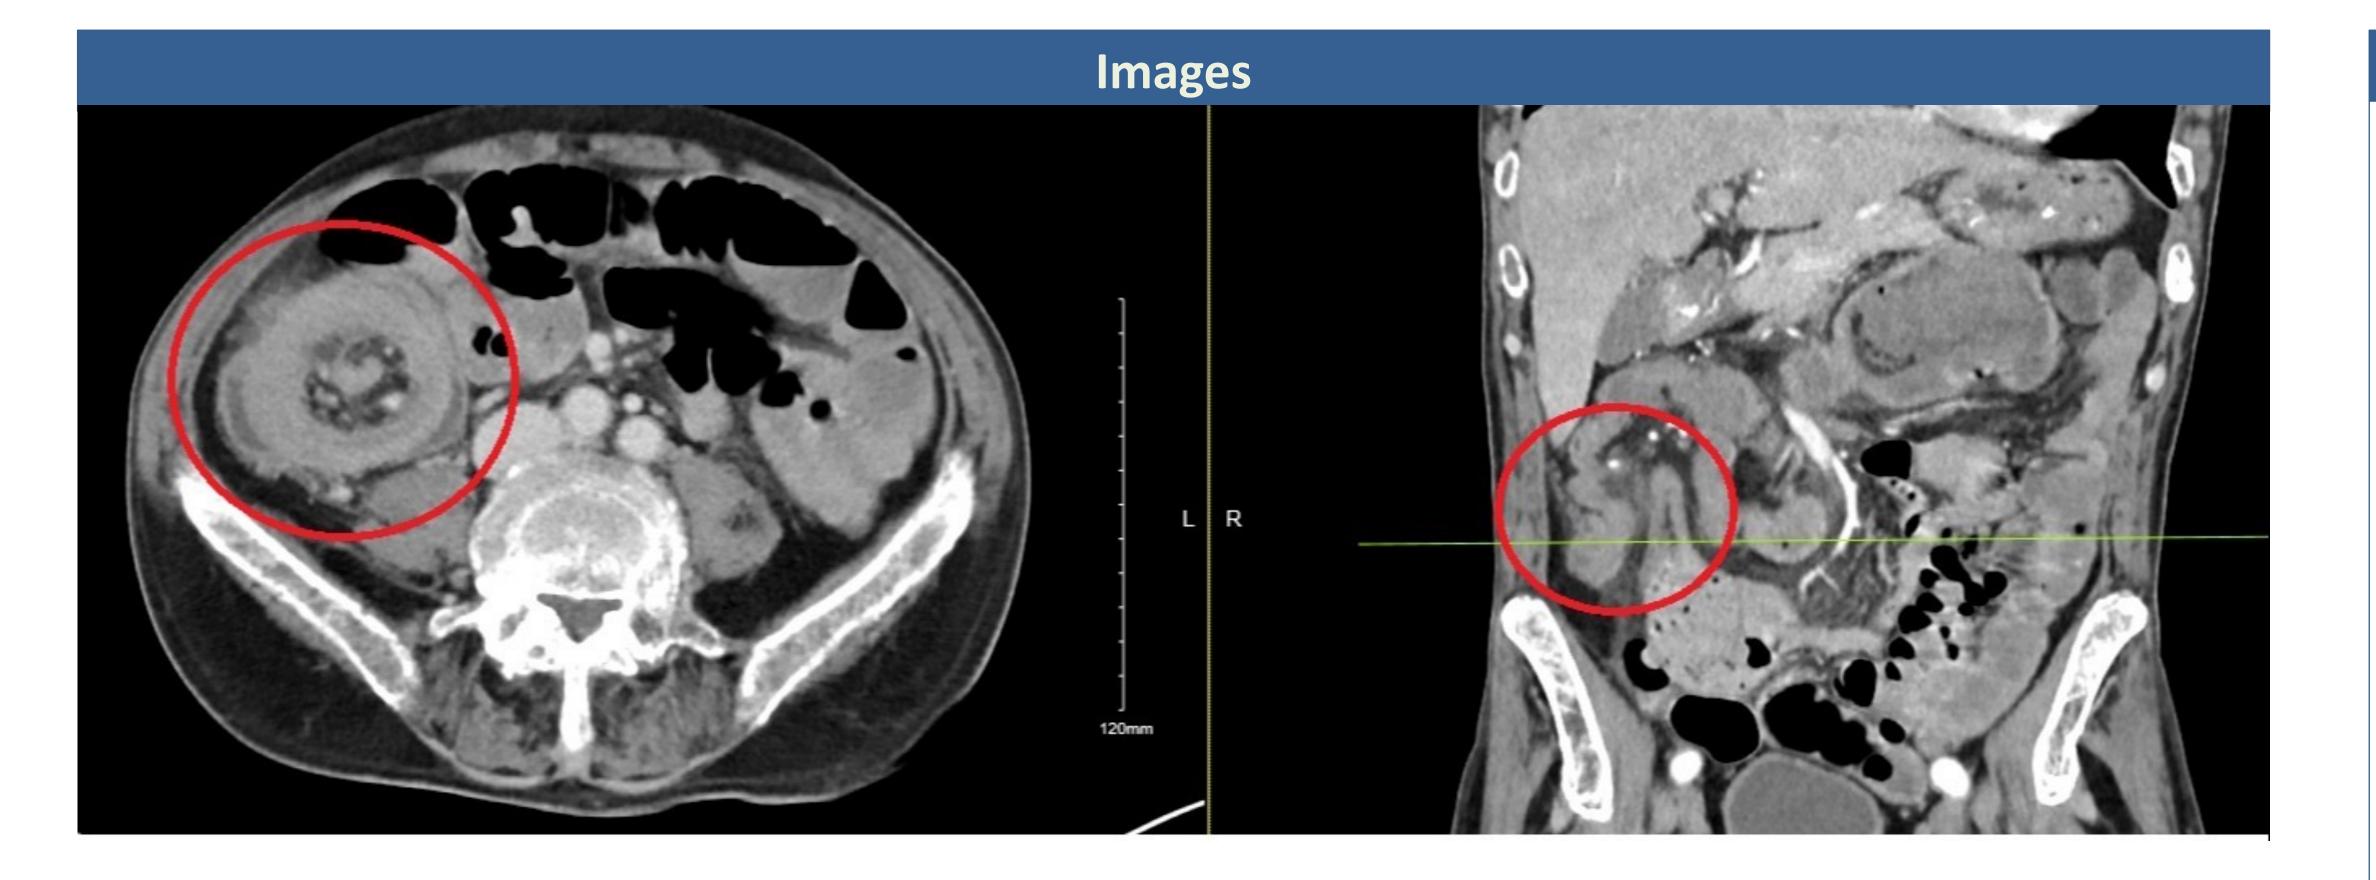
CT abdomen showing ileocecal intussusception with classic target sign on axial view
